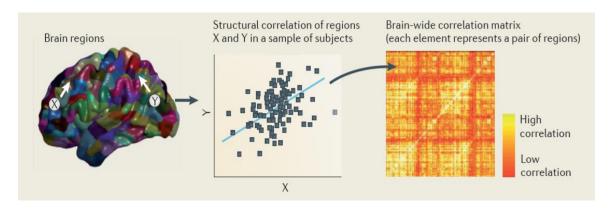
Overview of structural co-variance measurement in human brain MRI data. With permission from Alexander-Bloch (2013).
